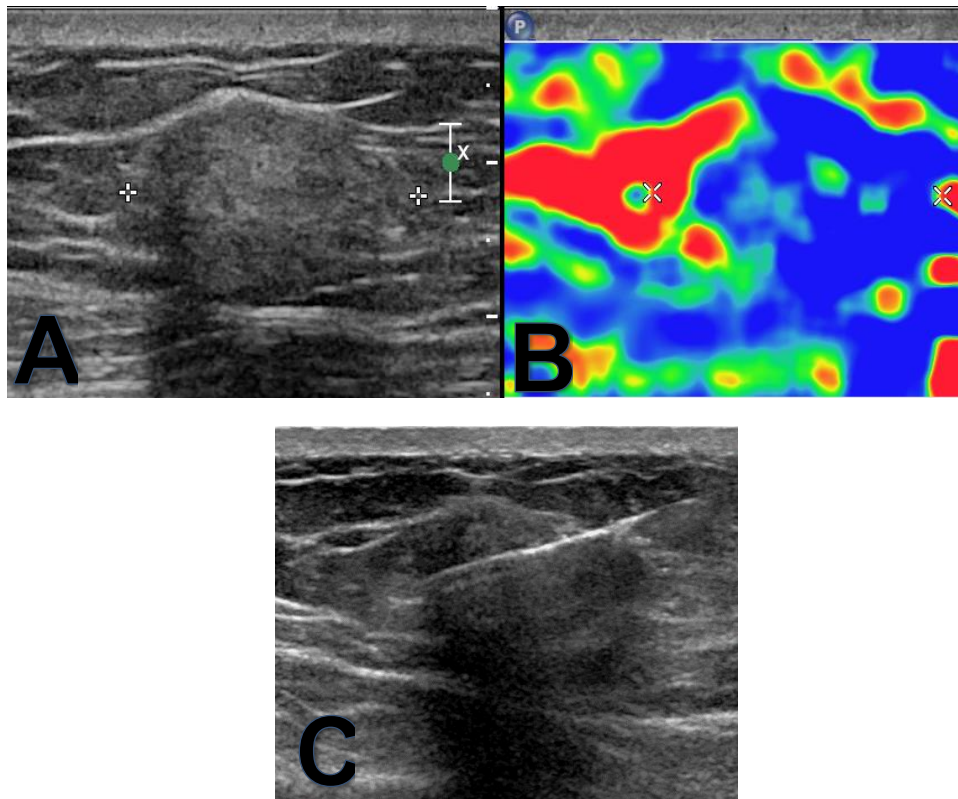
Grey scale ultrasound and elastography (Image A&B) in the area of palpable abnormality in the left breast show an elongated hyperechoic smoothly margined mass parallel to the tissue planes that measures 2.3 cm × 1.2 cm × 2.0 cm. There are areas that are hard and areas that are soft by elastography. Ultrasound guided biopsy (Image C) using 14-gauge, coaxial biopsy gun, access into the hyperechoic mass was achieved and 4 core biopsy samples were obtained.
